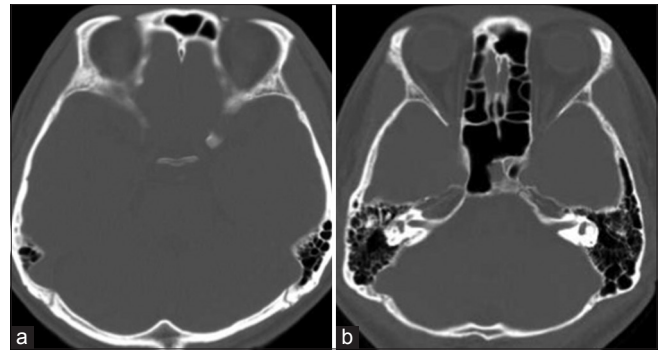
CT scan reveals (a) no intracranial air, and (b) no fluid accumulation in the sphenoid sinus during the follow-up period
